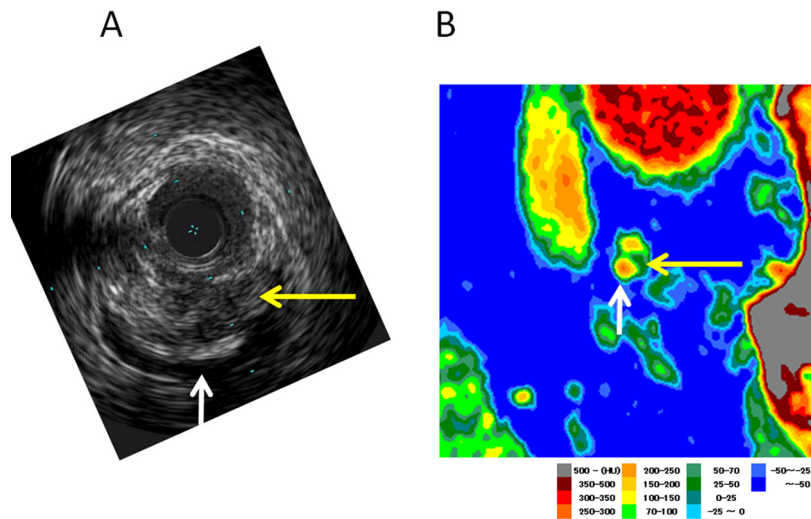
Intravascular ultrasound image (A) of the culprit and Plaque Map of the corresponding image (B). Media or adventitia do not show thickening.
